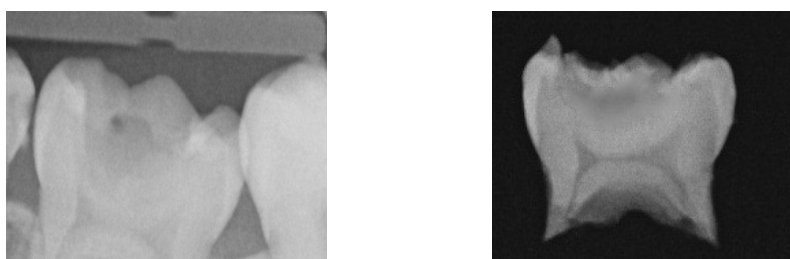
In-vivo (Left) & in-vitro (Right) radiograph showing RDT
